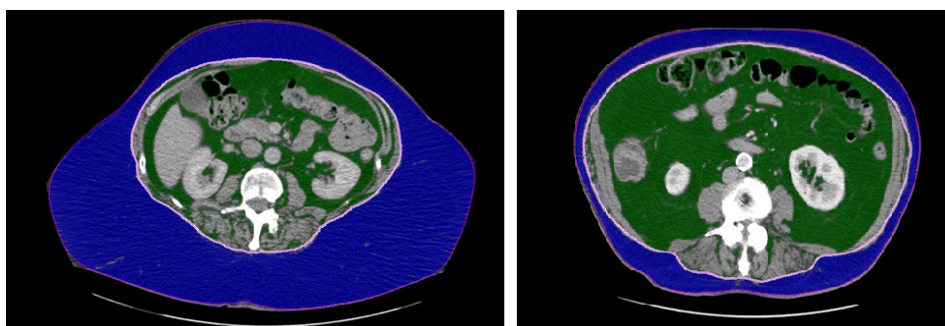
Cross-sectional abdominal CT image with segmentation of subcutaneous (blue) and visceral (green) body fat for measurements of body fat distribution in two endometrial cancer patients.
